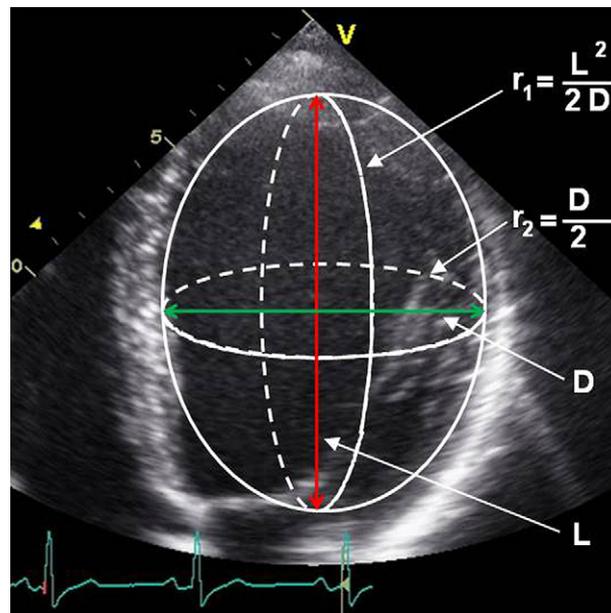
Two-dimensional echocardiogram from a patient with AR before AVR. Changes in LV shape are described by the principal radii of curvature, mathematically defined as $r_1 = L^2/2D$ and $r_2 = D/2$, where r_1 is the radius of the lateral wall long-axis curvature, r_2 is the radius of the circumferential short-axis curvature, L is LV length, and D is LV short-axis diameter.
